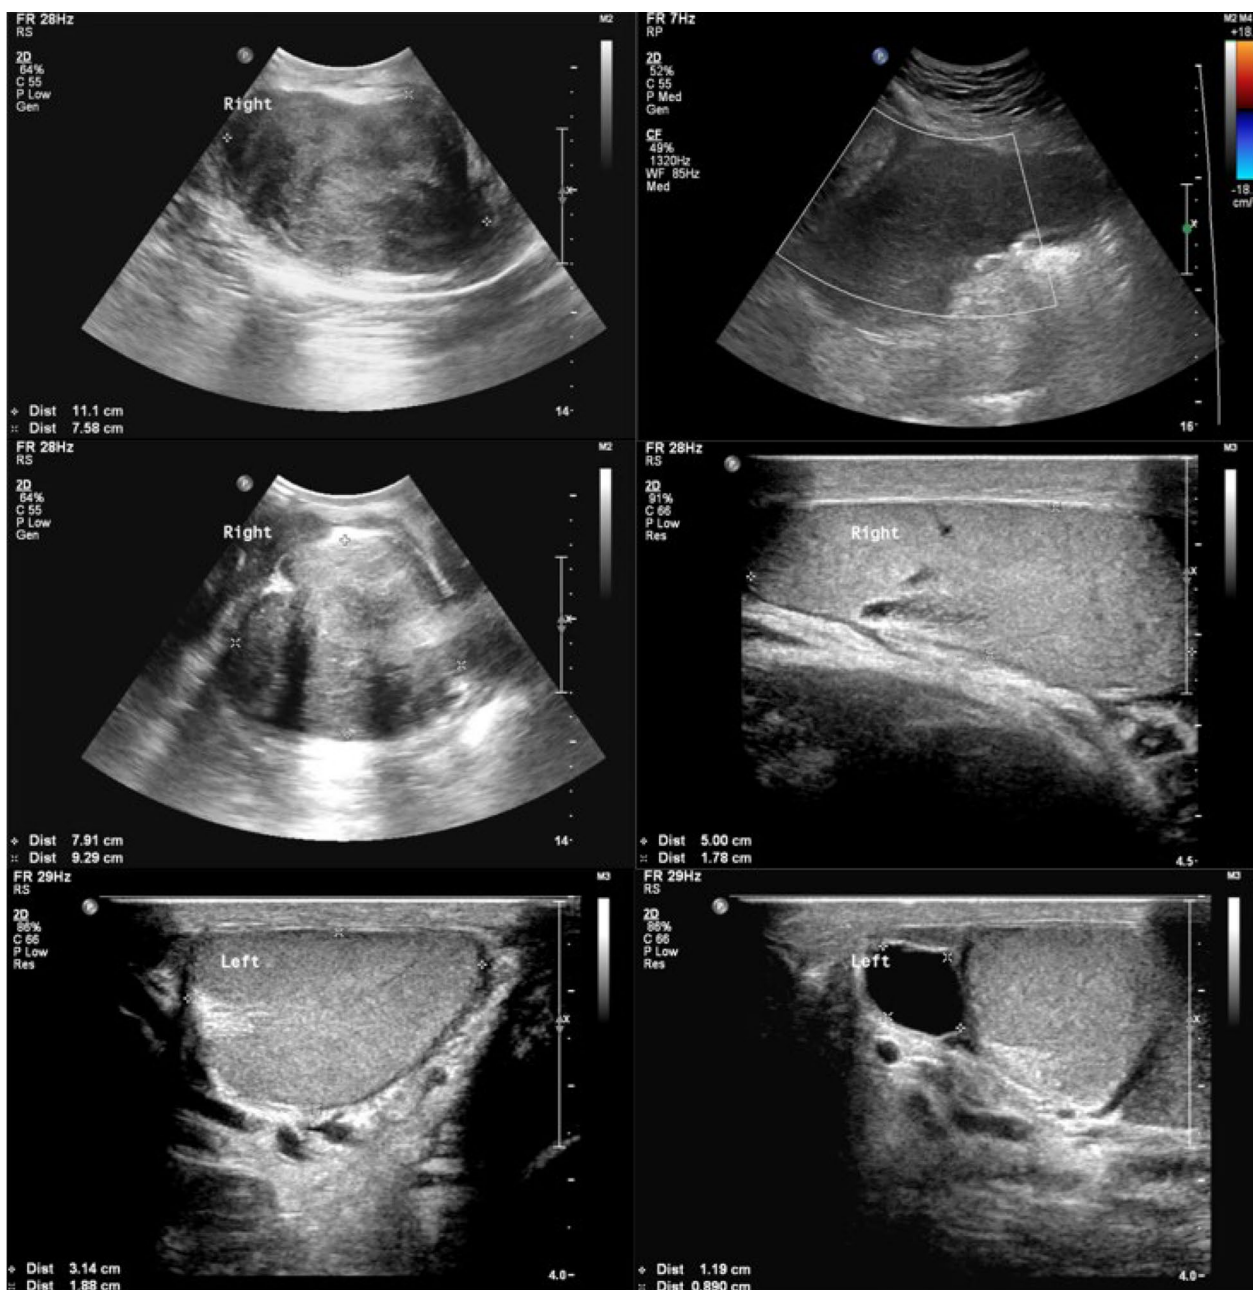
Testicular and inguinal ultrasound using both linear (7.5 MHz) and curvilinear (3.5 MHz) probes: heterogeneous right paratesticular and inguinal masses with mixed hyperechoic and hypoechoic echopattern. No significant internal vascularity by CDUS. Normal left testicle with a small epididymal cyst
